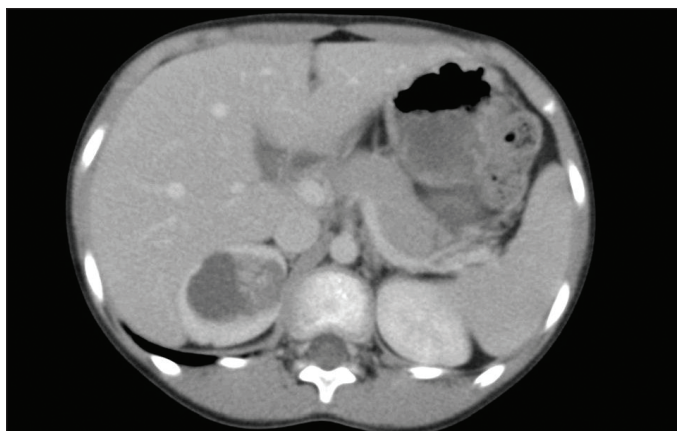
Computed tomography showing a heterogeneous cystic lesion with millimetric calcifications in the upper pole right kidney.
